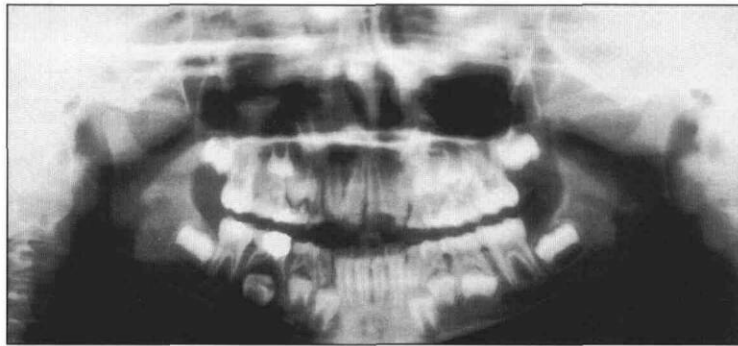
Panoramic radiograph showing dental development at age 7 years 8 months, nonvital right mandibular second primary molar.
